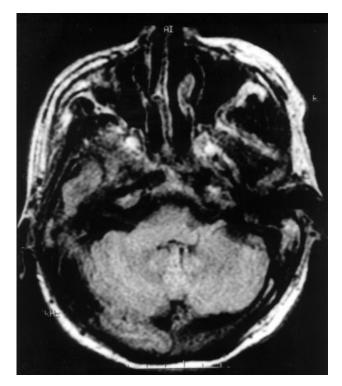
Magnetic resonance imaging in patient with *Bacteroides fragilis* meningitis prior to initiation of metronidazole therapy.
